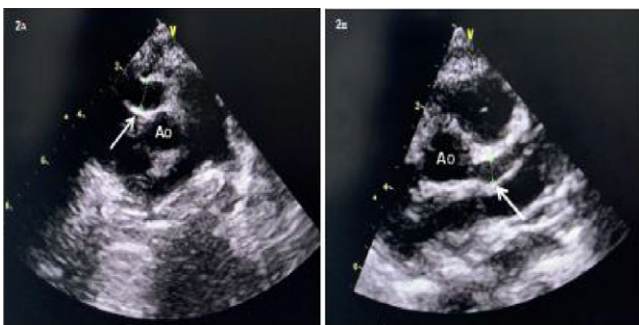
Two-dimensional Doppler echocardiogram. Parasternal short axis plane showing a large-size aneurysm of the left main coronary artery (2A: RMCA; maximum diameter of 8.5 mm; Z-score 11.62), and a small-size aneurysm of the right main coronary artery (2B: LMCA; maximum diameter of 5.1 mm; Z-score 6.97). Ao = aortic root.
